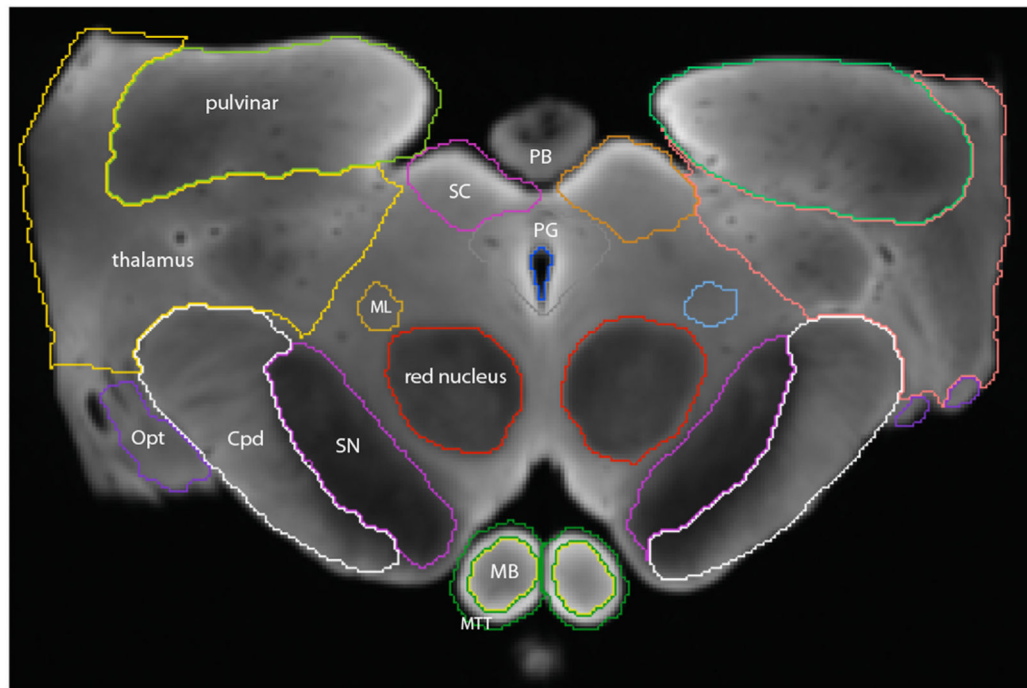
DWI image at the level of the mesencephalon demonstrating segmentation of various gray and white matter structures; image plane and orientation as in Fig. 2. Cpd, cerebral peduncle; MB, mamillary body; ML, medial lemniscus; MTT, mammillothalamic tract; Opt, optic tract; PB, pineal body; PG, periaqueductal gray; SC, superior colliculus; SN, substantia nigra.
